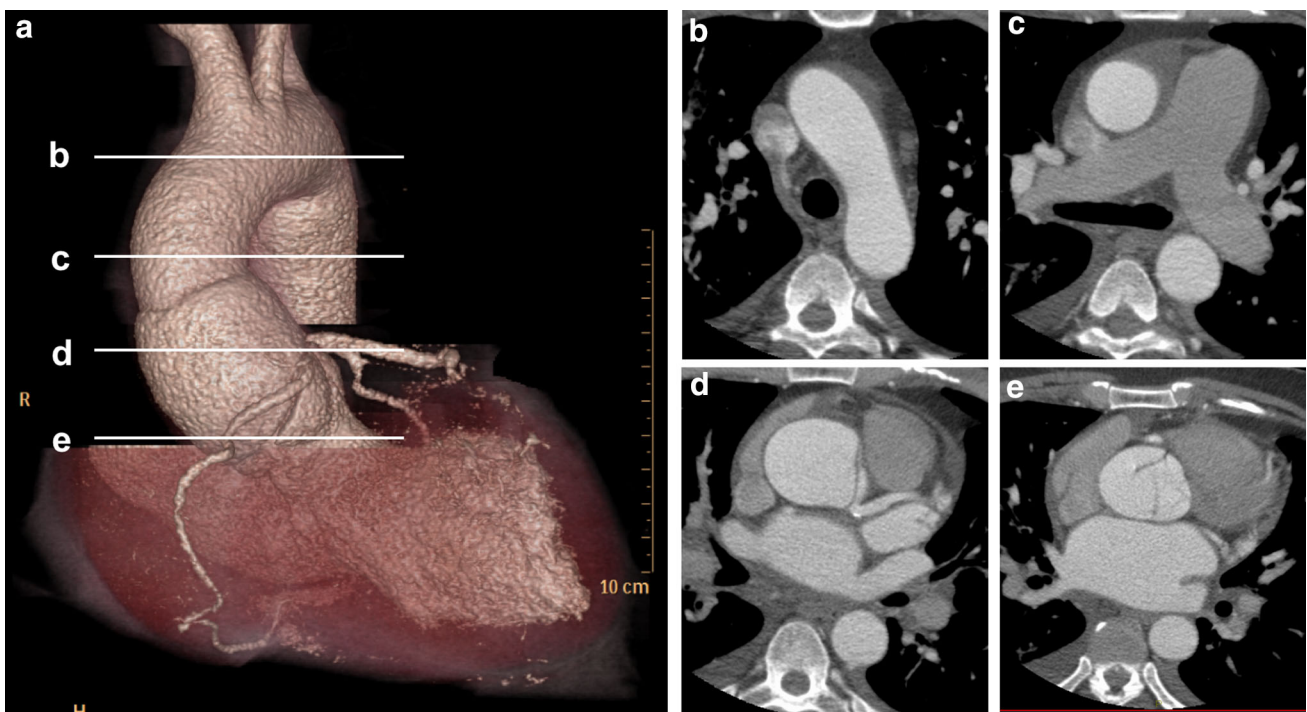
a Preoperative three-dimensional computed tomography shows dilated aortic root and no dissection at the ascending aorta and aortic arch. b–e This image shows the transverse plane at the level of the *white lines* in a. The dissected intima is detected only at the aortic root
